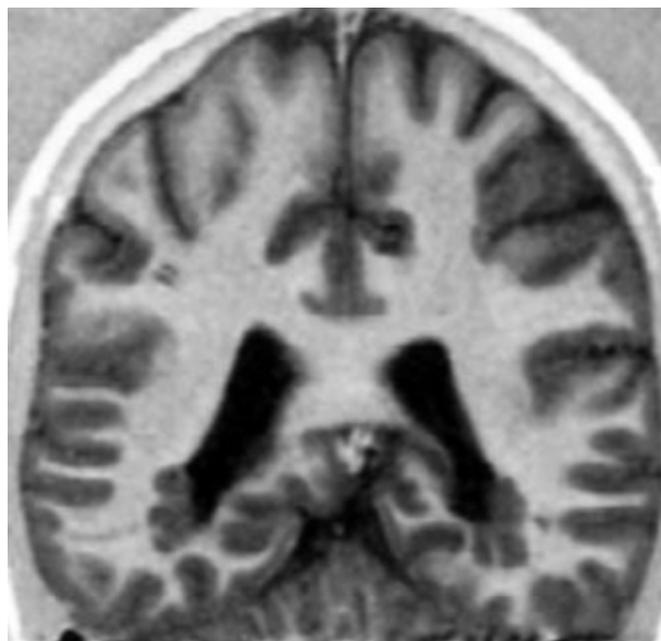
Coronal T1W MRI shows gray matter heterotopia lining the posterior ventricular system.
